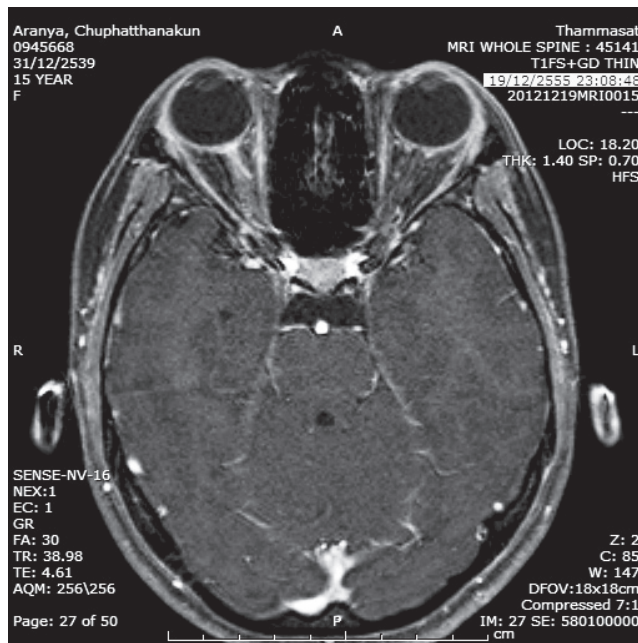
shows gadolinium-enhancing right optic nerve lesions in fat-suppressed T1-weighted orbital MRI.
